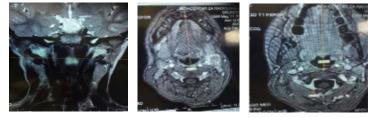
Magnetic resonance imaging (MRI) angiography of the head and neck showing an abnormal position of the left internal carotid artery (ICA) extending submucosally to the posterior wall of the pharynx.
